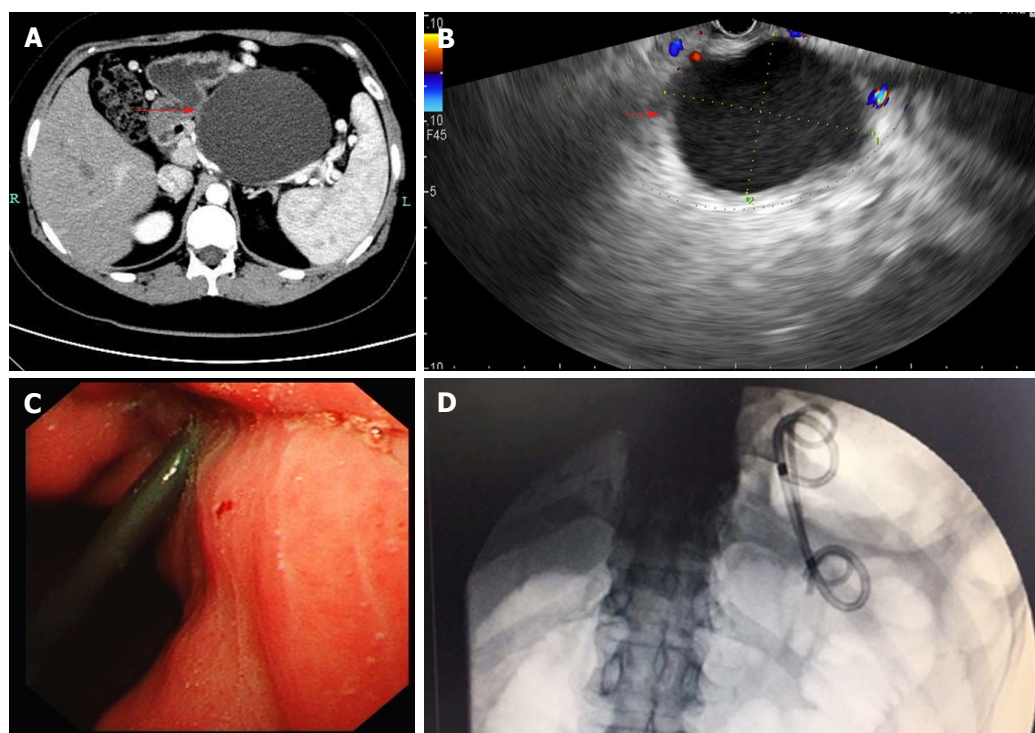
Imaging findings of pancreatic pseudocyst. A: A contrast-enhanced computed tomography (CECT) scan of the upper abdomen. A relatively homogenous cystic mass is identified in the region of the pancreatic tail (arrow). B: Endoscopic ultrasound (EUS) image showing a pancreatic pseudocyst (PPC) (arrow). C: Endoscopic image showing plastic stent deployment. D: Digital subtraction angiography (DSA) image revealing double pigtail plastic stent deployment.
